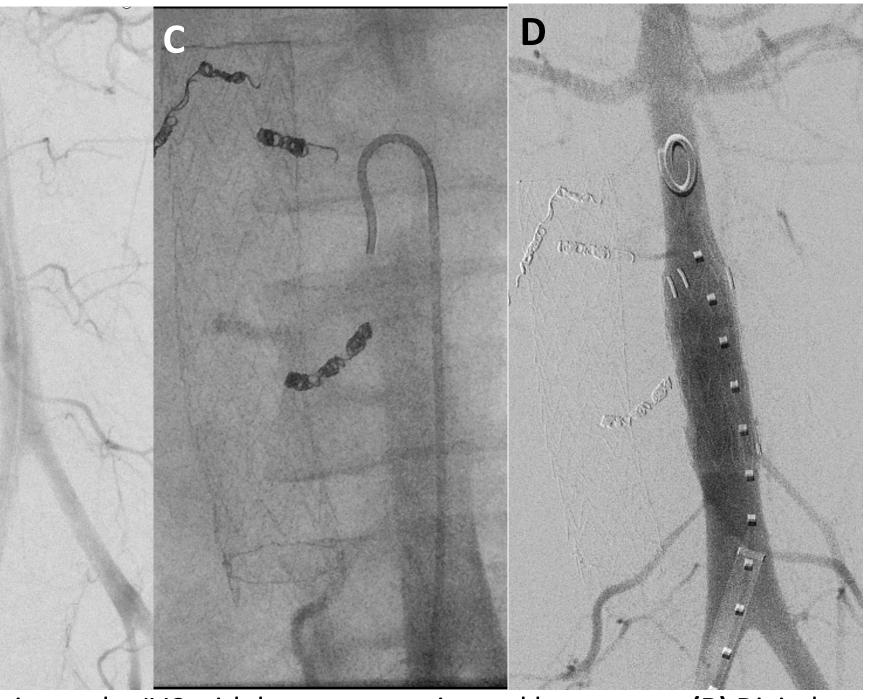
(A) Axial CTA showing active arterial phase extravasation anterior to the IVC with large retroperitoneal hematoma. (B) Digital subtraction angiography (DSA) image from abdominal aortogram showing a similar focus of extravasation (yellow arrow). (C) Spot fluoroscopic image showing persistence of the same focus of extravasation despite coil embolization of the right L2/L3 lumbar and gonadal arteries. (D) Final DSA image shows resolution of the extravasation after stent grafting of the aorta.
